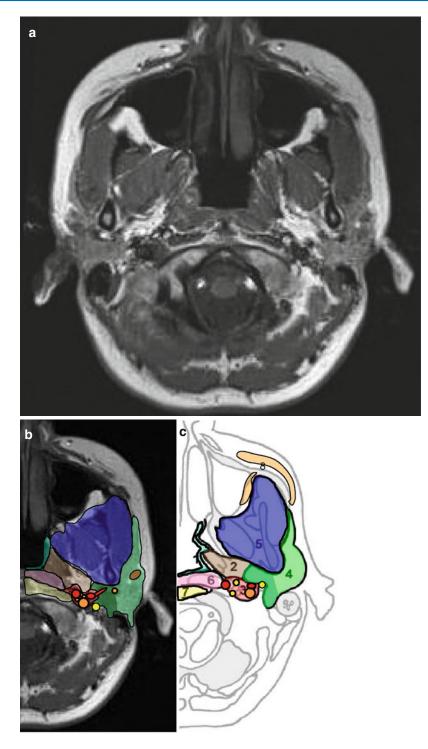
(a-c) MRI clearly depicts the neighboring soft tissue compartments of the parotideal region and therefore could precisely detect the infiltration of an extended parotid tumor into the surrounding structures. *I* uperficial
